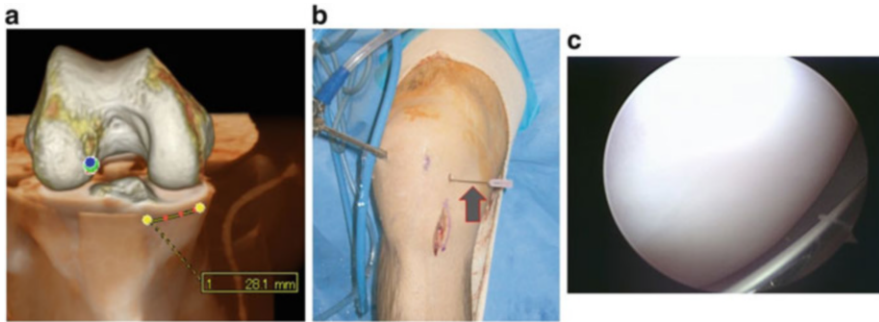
(a) This figure shows a typical 3D CT view represented using specialized software [Virtual Place Raijin (Aze Ltd., Tokyo, Japan)]. Such imaging is used for preoperative assessment of the optimal position of the skin incision for this portal that would allow creation of the femoral tunnels within the confines of the anatomical ACL femoral footprint to avoid scuffing the articular cartilage of the medial femoral condyle. Usually the skin incision for this portal is located just superior to the medial joint line about 2.5 cm medial to the medial border of the patellar tendon. (b) FAM portal according to the 3D CT view. (c) Direction should be monitored when the guide needle is inserted, to avoid cartilage damage
